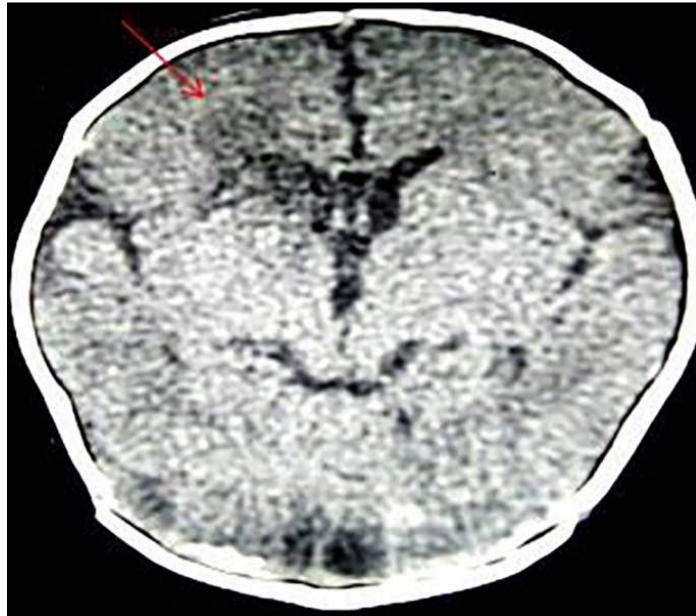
Brain CT: An infant of 38 week's postconceptional age with meningitis and seizure, low attenuation areas around the right lateral ventricle and at caudate head, which was suggestive of hypoxic ischemic insult
